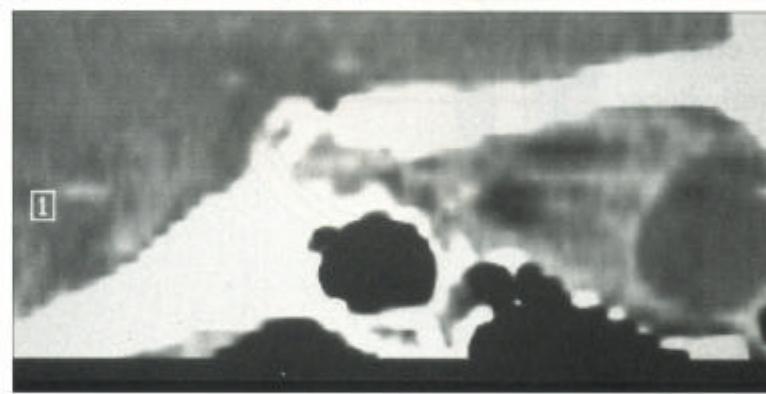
Axial and coronal high-resolution CT scans of the orbit demonstrate the orbital bone tents. Coronal and sagittal cuts are extremely useful in the assessment of lesions in the inferior or superior orbit and the orbital apex, and for planning surgery.
